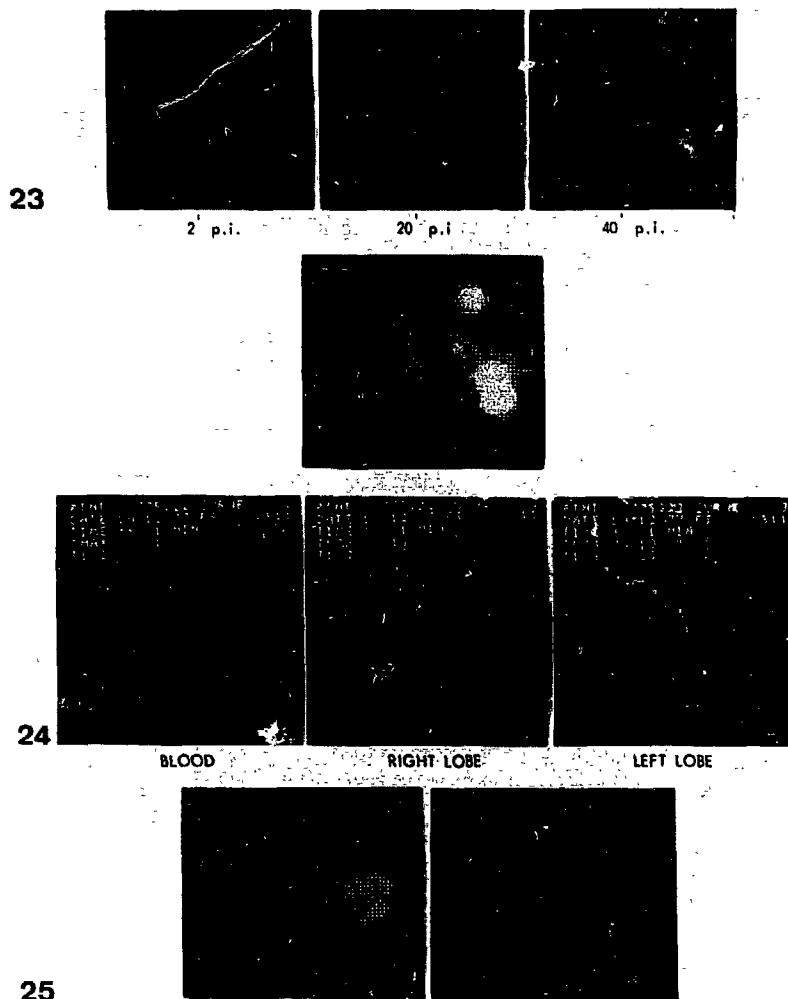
23-25 Cholescintigraphy in a patient with a hemangioma
